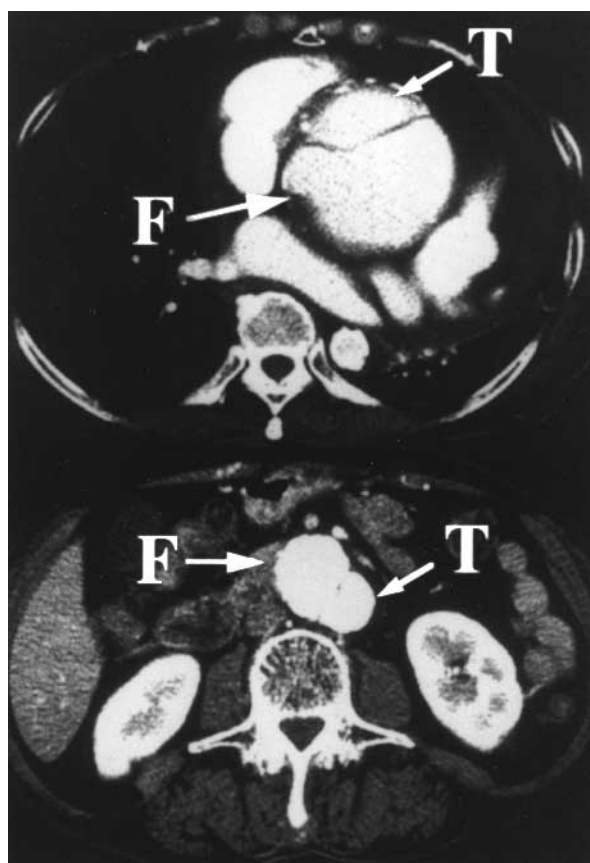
Preoperative CT findings. Aortic dissections were localized in the ascending aorta (Stanford type A) and the abdominal aorta, and CT showed marked calcification of the descending aorta. T, True lumen; F, false lumen.
